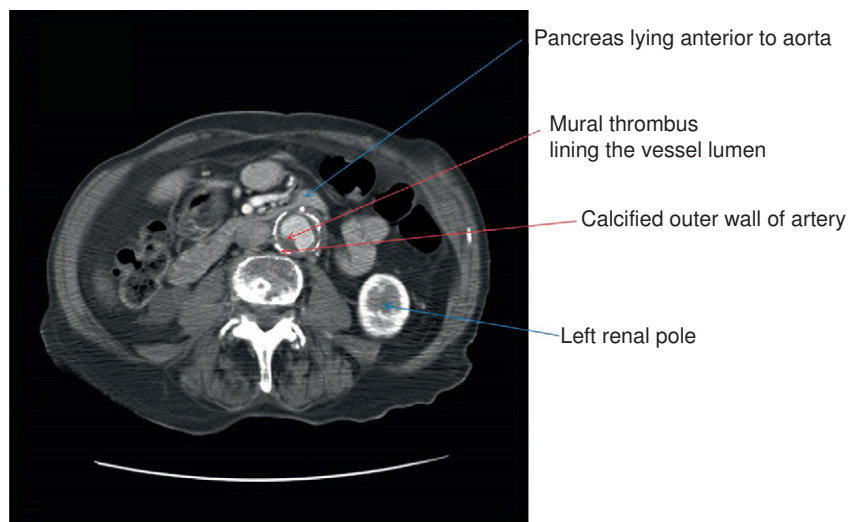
CT scan of the abdomen.
